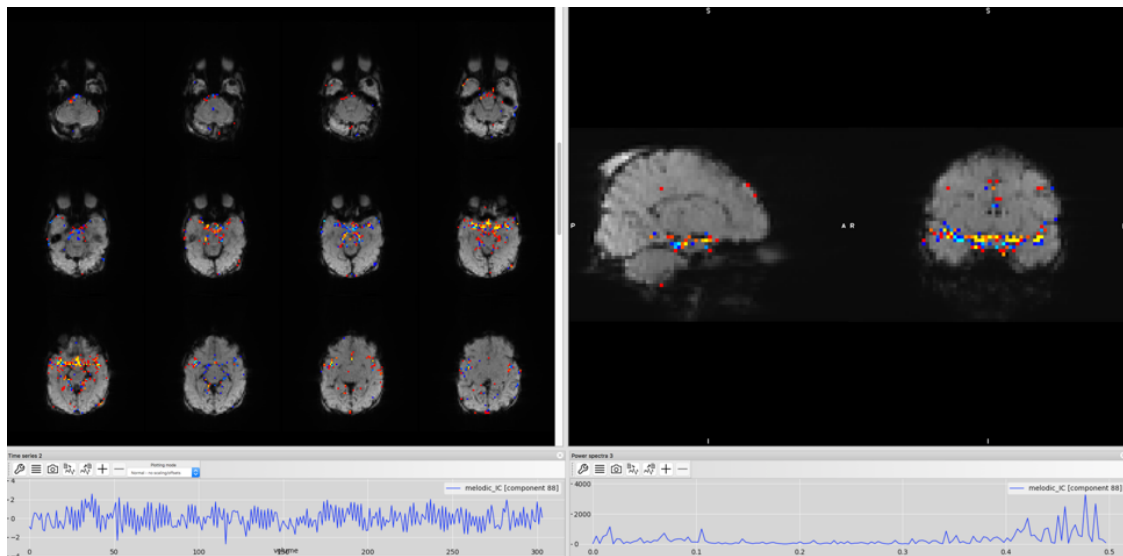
MRI-related artefact
